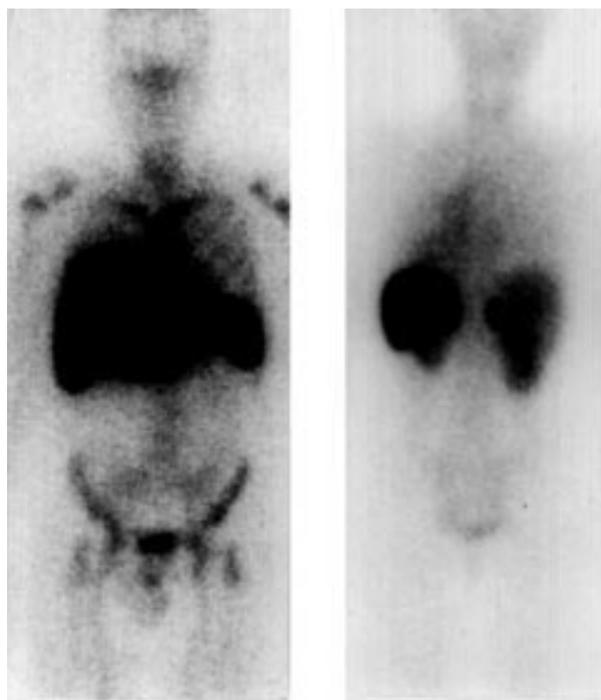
Whole body ¹²⁵I-SAP scintigraphy in amyloidosis. Left: anterior image of a 26 year old man showing uptake of tracer into substantial liver, spleen, and bone marrow amyloid, a distribution diagnostic of systemic AL amyloidosis. Right: posterior scan showing AA amyloid deposits in the spleen, adrenals, and kidneys of a 34 year old woman with rheumatoid arthritis.
